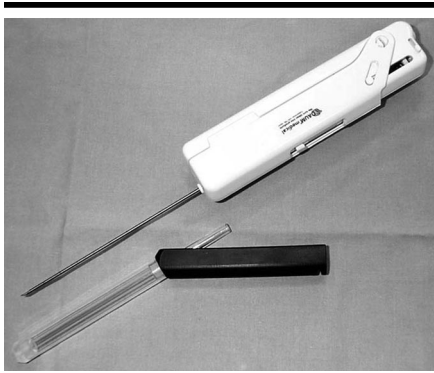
Photograph shows biopsy needle and needle guide used for MR imaging–guided biopsy. The needle is inserted after the contrast material–filled needle guide is locked in the desired position.
